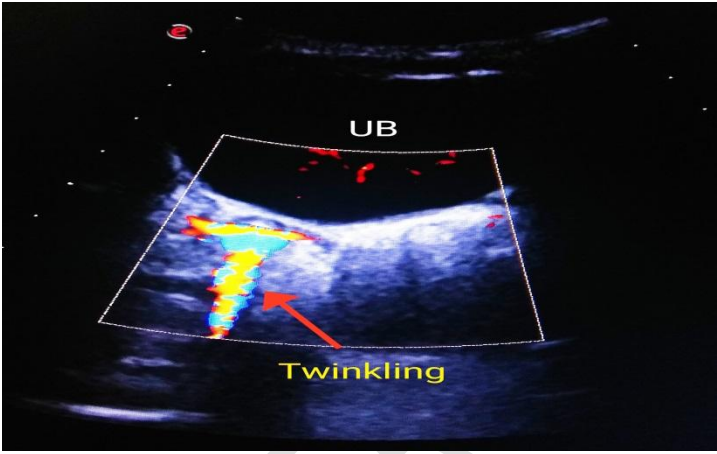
Ultrasound image showing 'Twinkling' artifact of calculus on color Doppler.
